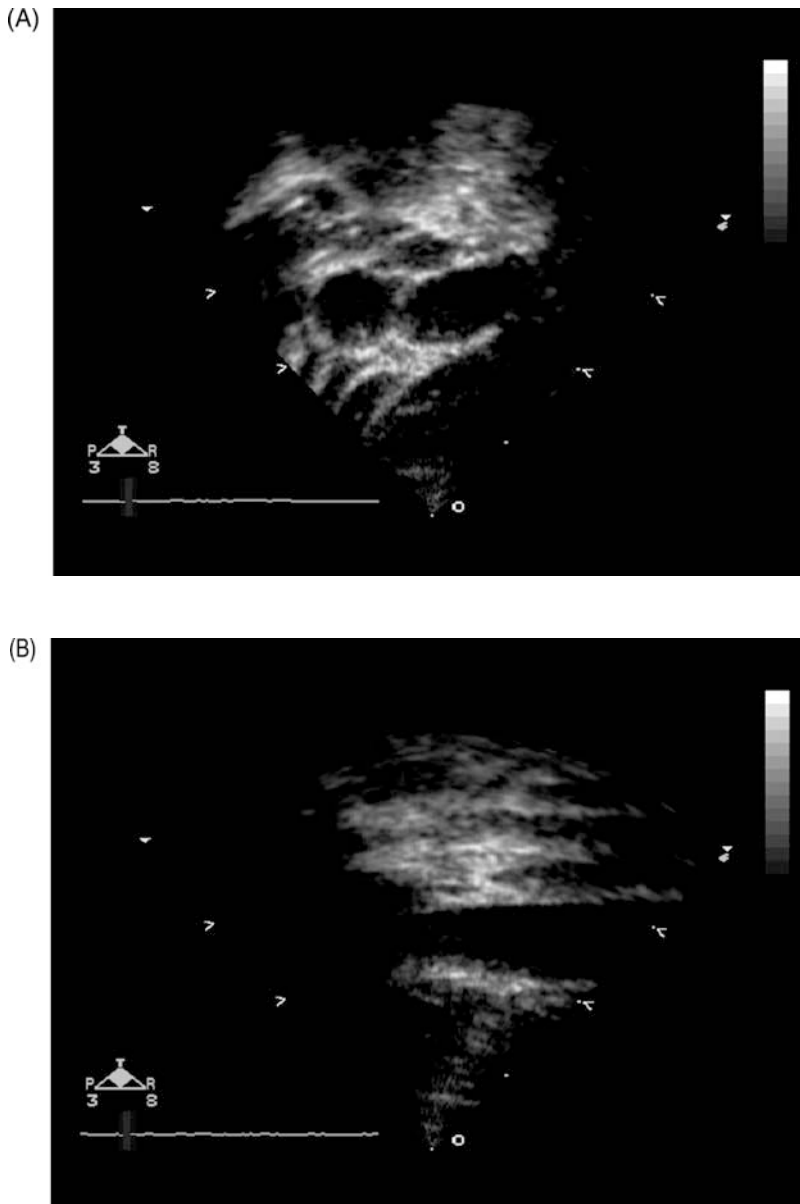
Cross-sectional ultrasound of the right neck in a supine patient shows a round common carotid artery medially and an adjacent, slightly flattened internal jugular vein, A. After centering the probe on the IJ rotation of the probe provides a "long axis" view, B
